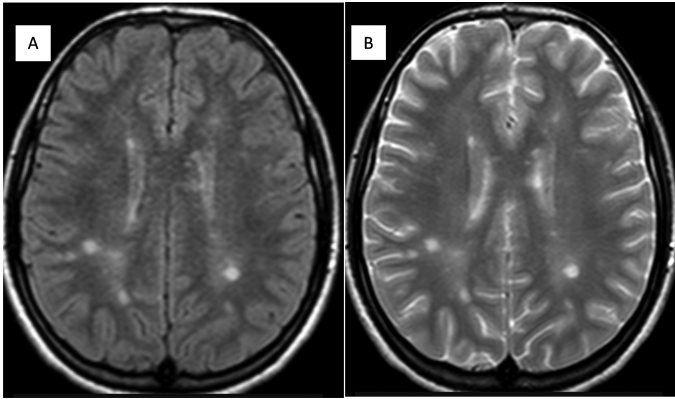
A 11-year-old girl was diagnosed with acute disseminated encephalomyelitis (ADEM). She had hyperintense plaque formations in the periventricular white matter and the centrum semiovale. (A) T2 Weight Imaging T2WI and (B) Fluid attenuation recovery FLAIR scans.
